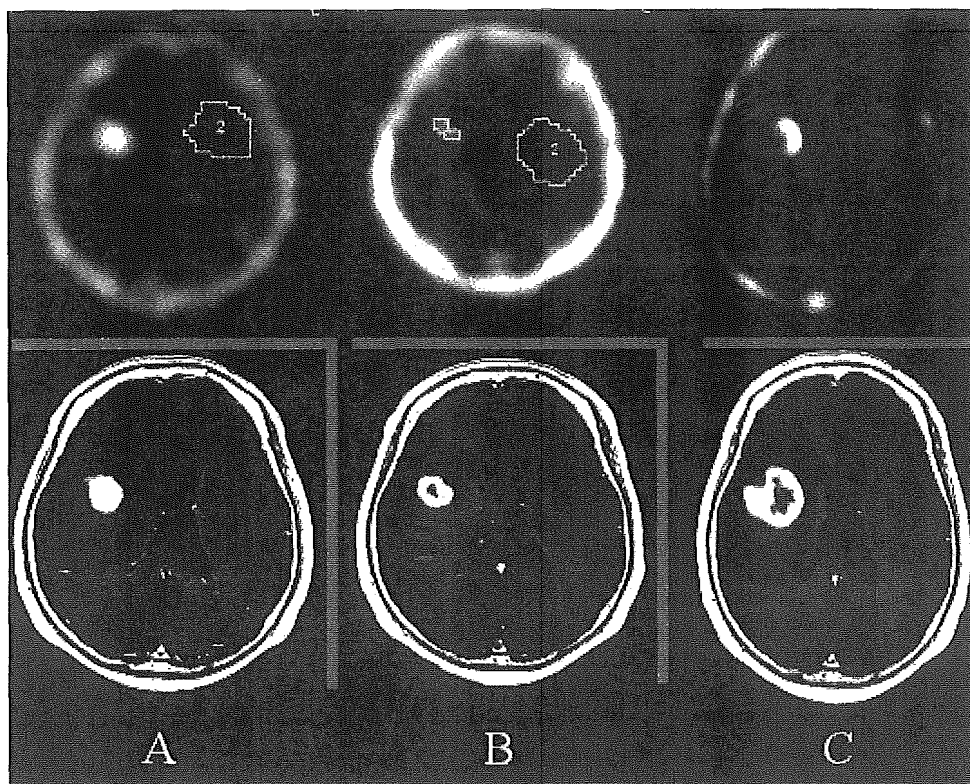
Serial enhanced MR and ²⁰¹Tl SPECT studies obtained in the patient in Case 1. A: Pre-GKS: a right frontal metastatic lesion from colon cancer. The Tl accumulation was intense (Tl index 11.43). B: Two months later: the tumor shows shrinkage and the Tl index has decreased to 2.75. C: Seven months later the tumor has increased in size and the Tl index has risen to 5.8. The radioisotope diagnosis was tumor recurrence. The tumor was resected.
